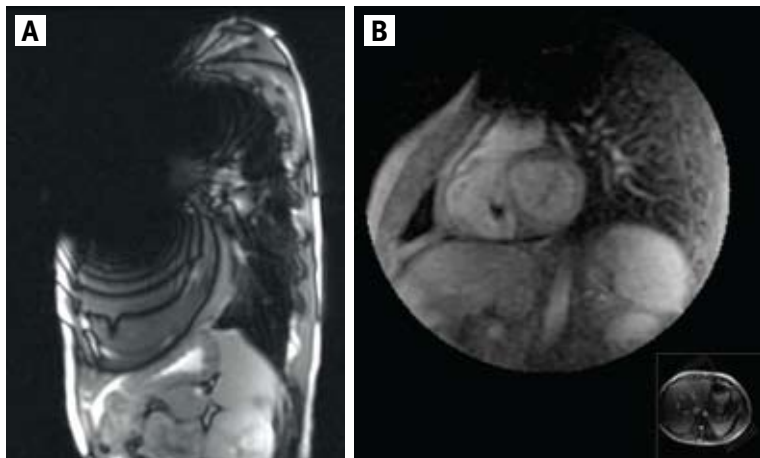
[A] Cardiac MRI (non-gated localizers) in sagittal plane in an 11 year old boy. Significant susceptibility artifacts project from the chest wall obscuring the heart, rendering this study non-diagnostic (the scan was stopped). [B] Cardiac MRI in oblique plane in a 35 year old man is of acceptable diagnostic quality, and susceptibility artifacts projected from the chest wall obscure only the upper most part of the heart.
